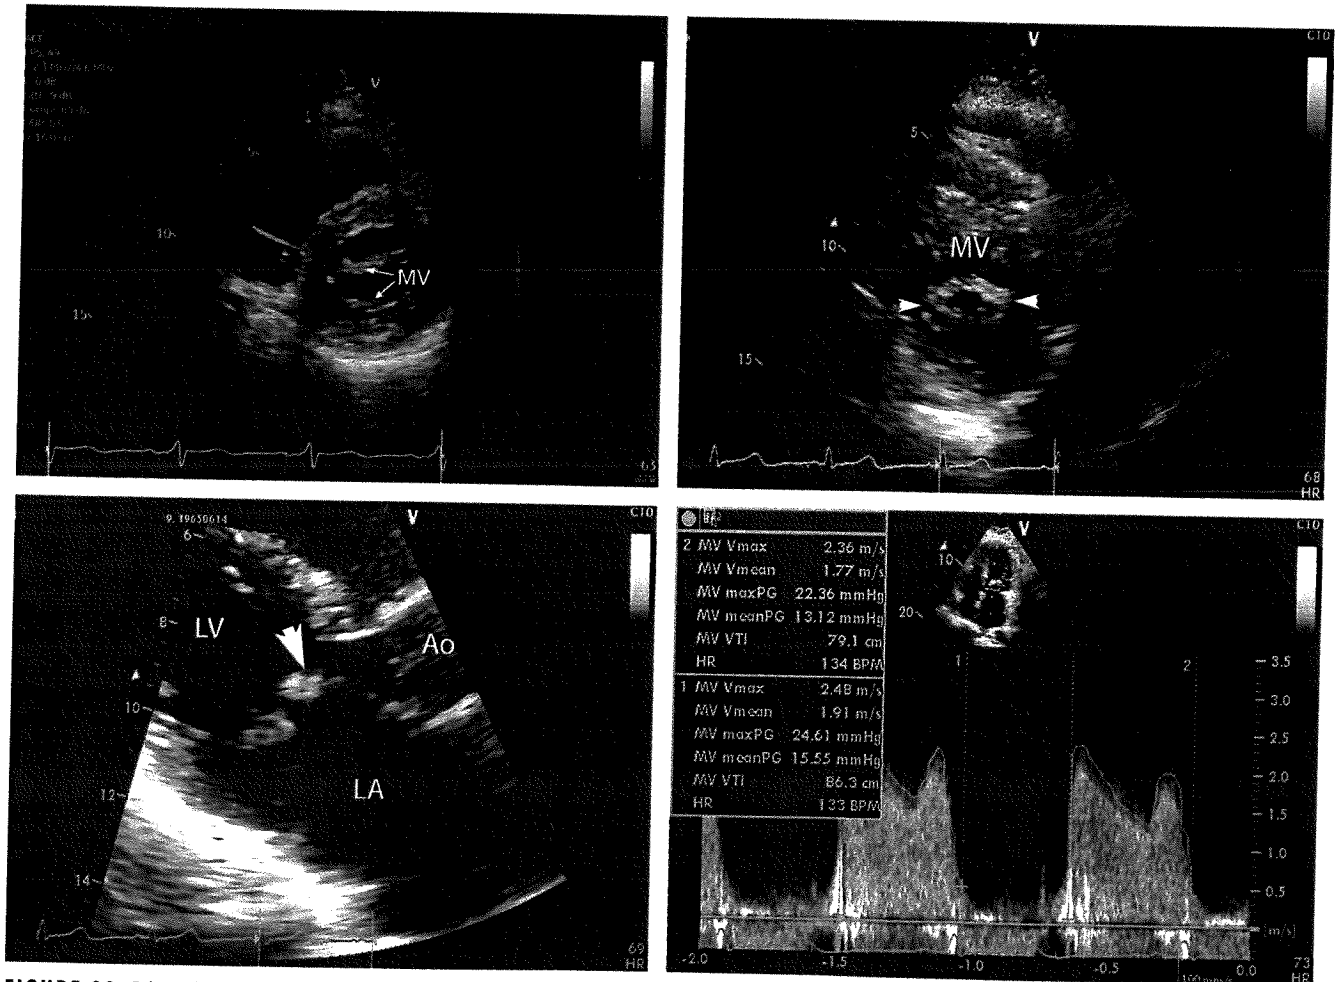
Echocardiograms showing a normal mitral valve (MV) (top right panel) and rheumatic mitral stenosis with commissural fusion (arrowheads, top left panel). In the bottom left panel, diastolic doming (arrowhead) is present with a "hockey stick" deformity from mitral stenosis. In the bottom right panel, a Doppler echocardiogram shows a mitral gradient of 13 mm Hg, consistent with severe stenosis. Ao = ascending aorta; LA = left atrium; LV = left ventricle.
